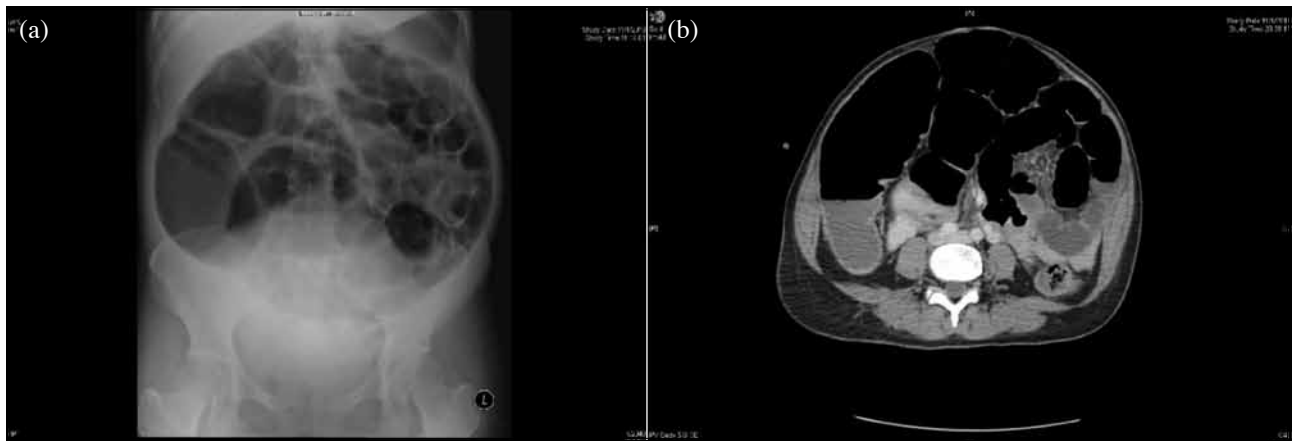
(a) Radiograph and (b) computed tomography image of the abdomen and pelvis showing dilated large bowel at the transverse colon, with suspected transition point at the sigmoid colon posterior to uterus.
